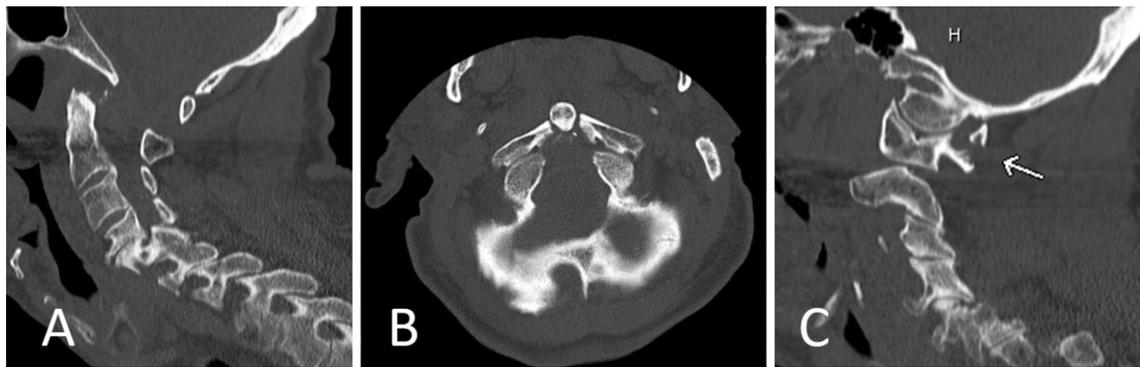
CT Cervical spine, mid-sagittal (a), axial (b) and parasagittal (c). The intact odontoid process has displaced through the anterior arch of atlas. There is posterior displacement of C1 on C2, consistent
